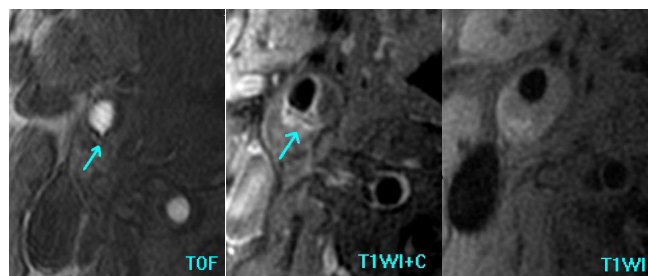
In TOF MR images, at the region of FC rupture, the dark band is absent and there is a region of hyperintense signal adjacent to the lumen. In post-CE T1W MR images, a region of strong enhancement adjacent to the lumen indicates a ruptured FC with or without associated neovasculature.
